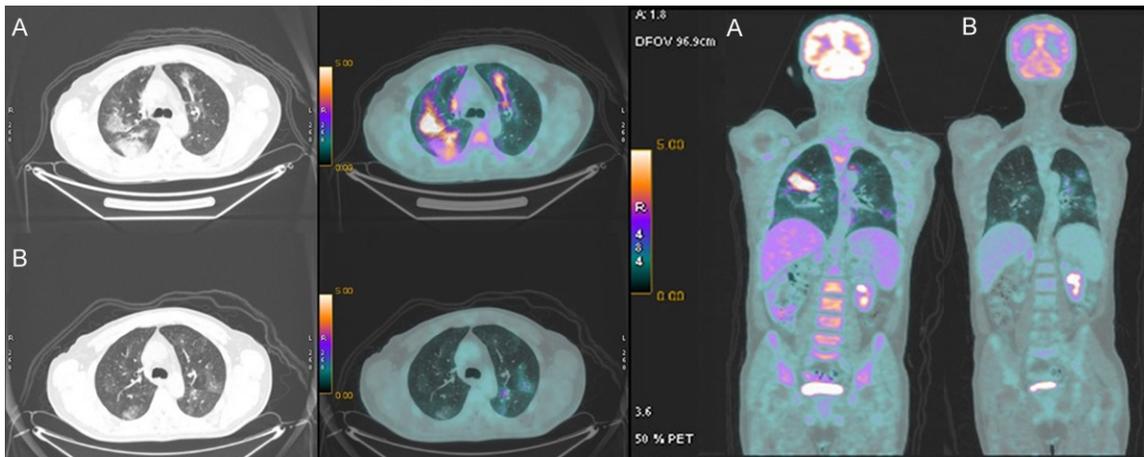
^{18}F -FDG PET/CT use in diagnosis and monitoring of lung inflammation caused by SARS-CoV-2. Male, 48 y/o, had follicular lymphoma. He was given chemotherapy until April, 2020 and is currently receiving rituximab. In June, he had mild flu-like symptoms and tested positive for COVID-19. After 17 days, due to a persistent daily fever, a ^{18}F -FDG PET/CT was performed and demonstrated glycolytic hypermetabolism in areas of multiple opacities with “ground-glass” attention and sparse pulmonary consolidations with air-permeable bronchograms in both lungs (A). These findings were related to COVID-19 and not to lymphoma. One month later, the patient presented clinically well, although with persistent fever episodes. He underwent another ^{18}F -FDG PET/CT that has shown impressive improvement of pulmonary inflammatory lesions and no lymphoma evidence (B) (images from the authors' personal files).
